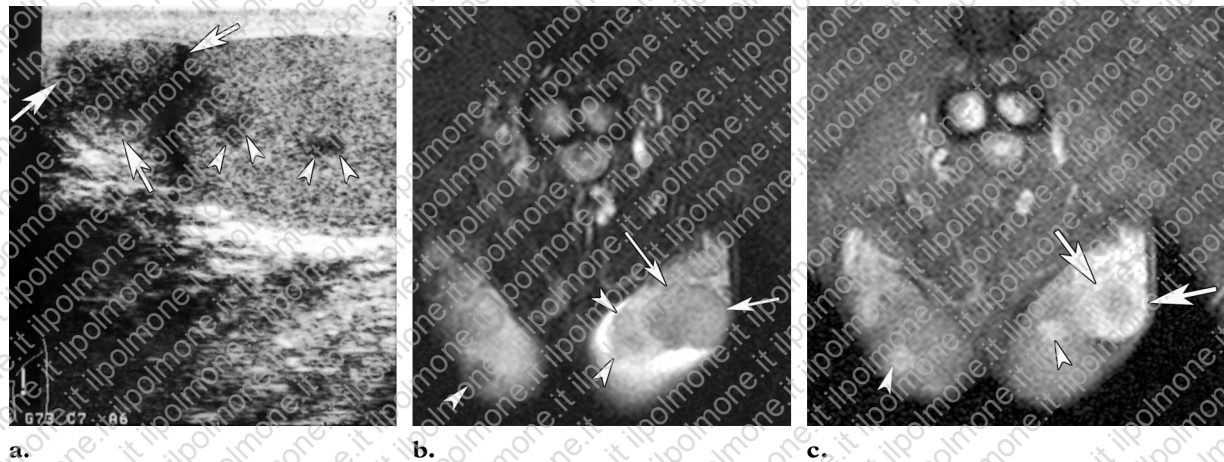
Intrascrotal sarcoidosis in a 16-year-old boy who presented with epididymal pain and swelling. (a) US image of the scrotum (longitudinal view) demonstrates a markedly enlarged left epididymis (arrows) and multiple hypoechoic nodules in the left testis (arrowheads). (b, c) T2-weighted (b) and contrast-enhanced (c) MR images show an enlarged left epididymis (arrows) and multiple nodules in both testes (arrowheads). The nodules are hypointense on the T2-weighted image and demonstrate enhancement on the contrast-enhanced image.
